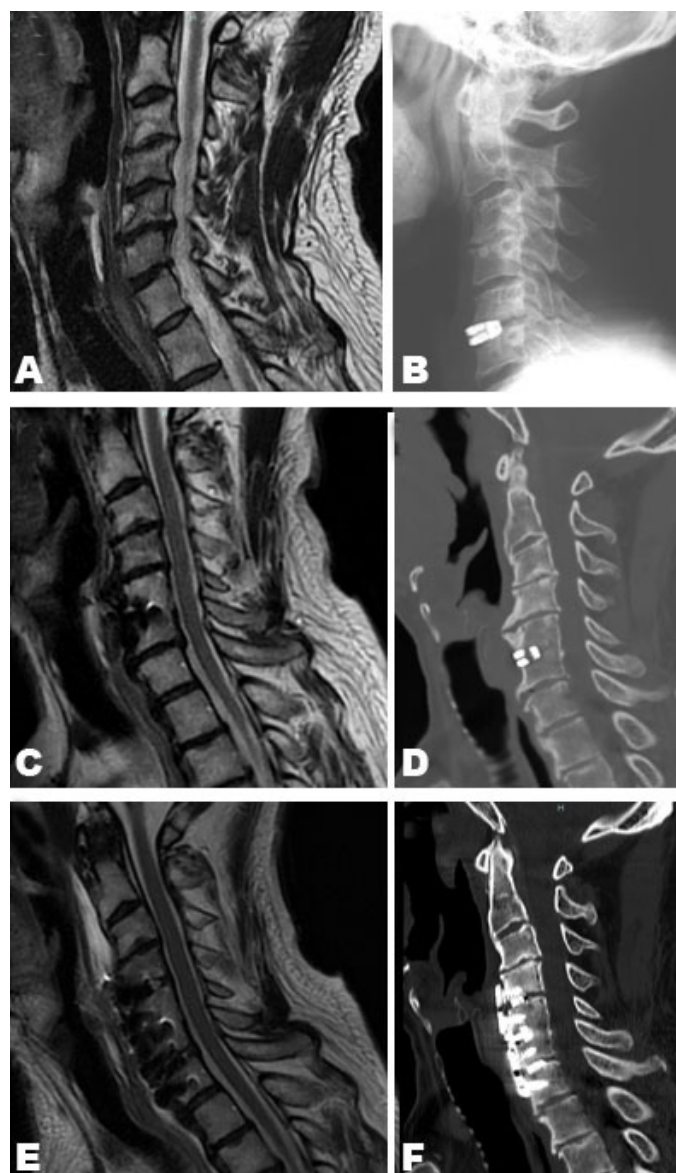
The cervical features are documented. (A) shows a lateral view of the cervical portion obtained via T2-weighted MRI 13 years prior to the present time. Spinal canal stenosis at the C5–C6 level due to lumbar herniation is observed. (B) shows an x-ray taken after the first ACDF procedure. The cervical disc was replaced with a cage at the C5–C6 level. (C) shows the cervical portion by T2-weighted MRI at the present time. Spinal canal stenosis is not observed. (D) shows the cervical region via CT scan at the present time. Anterior protrusion with calcification is observed at the C4–C5 and C6–C7 levels. (E) shows the cervical portion by T2-weighted MRI after the additional operation. (F) shows the cervical portion by CT scan after the additional operation.
